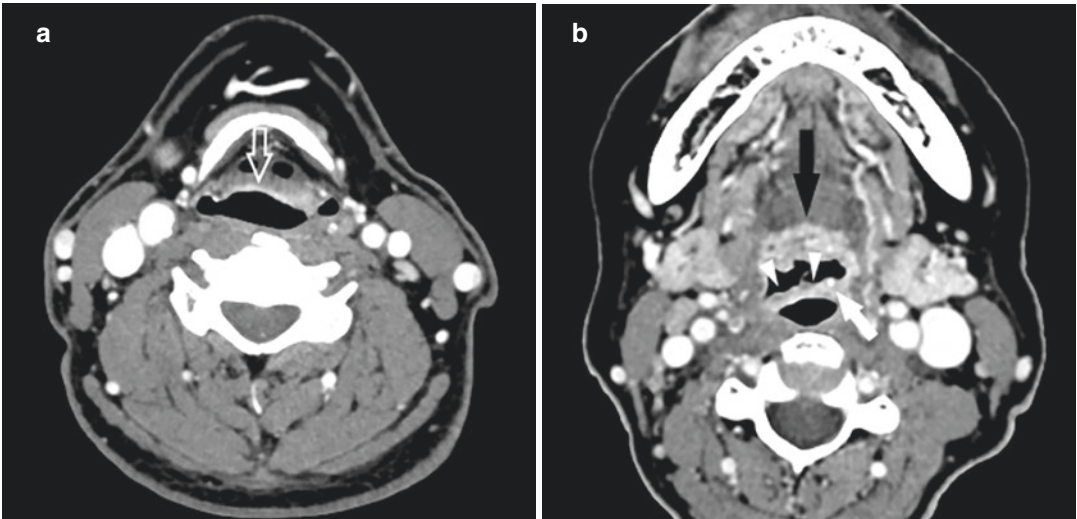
Epiglottic involvement in laryngeal tuberculosis in two different patients. (a) Axial contrast-enhanced CT image shows diffuse, smooth thickening of the epiglottis with enhancement of the laryngeal surface (open arrow). (b) Axial contrast-enhanced CT image in a different
